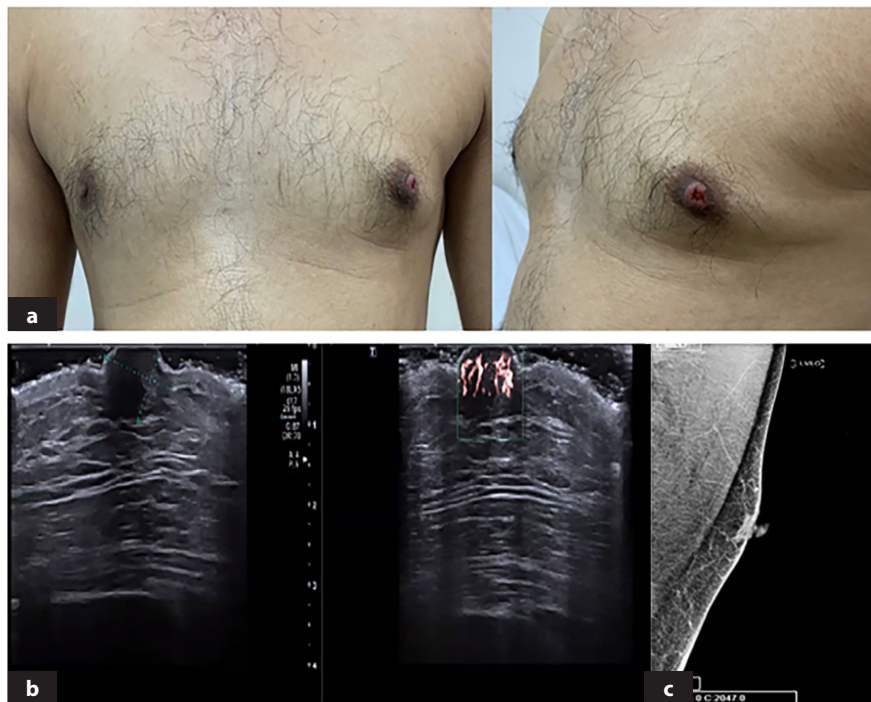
Clinical and radiological images of nipple adenoma. a) Hyperemia and serous discharge in the left nipple. b) On ultrasonography, the volume of the left nipple has increased and is 6x9 mm, the skin-subcutaneous tissues are eroded, with the central nipple showing a hypoechoic appearance with a diameter of 2.2 mm, suggesting a dilated duct with dense content in the foreground. c) In mammography, there are no findings other than prominence in the left areola.
